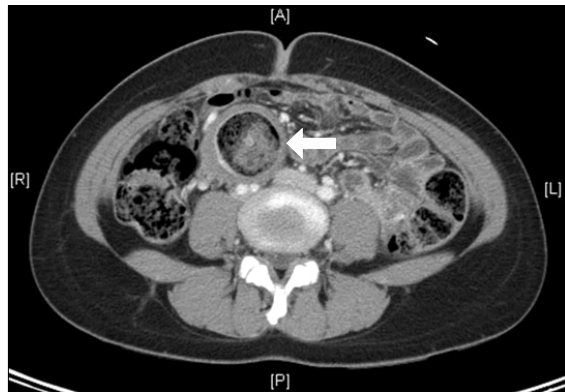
Axial view abdominal computed tomography scan showing thickened bowel wall (white arrow) and segmental dilatation with stasis of intraluminal content.
